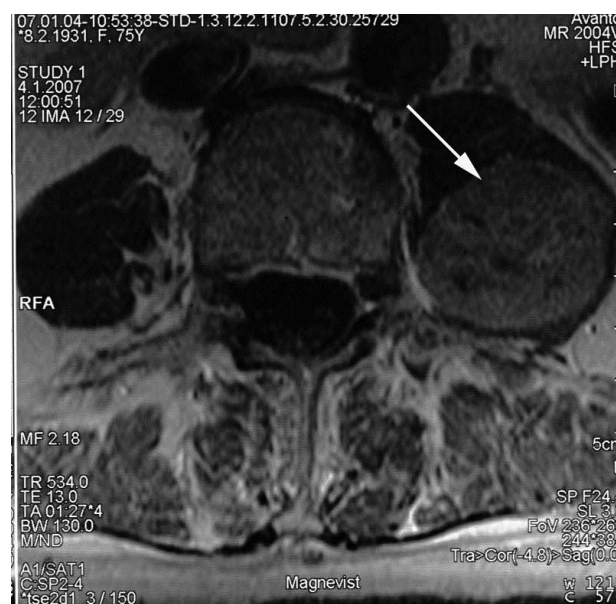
Magnetic resonance imaging (MRI) of a large expansive mass in the left lumbar paraspinal area.
